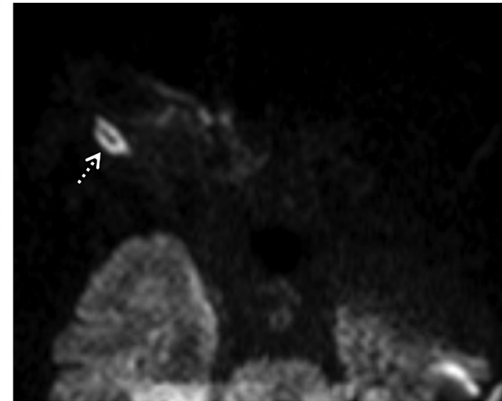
Intraorbital abscess in a 45-year-old woman. (a) Axial contrast-enhanced CT image of the orbits reveals right proptosis with globe deformity (the “guitar pick” sign) and periorbital edema with a rim-enhancing fluid collection (arrow) in the right lateral extraconal space. (b) Axial contrast-enhanced T1-weighted MR image shows the rim-enhancing fluid collection (arrow) abutting and displacing the right lateral rectus muscle. (c) Axial diffusion-weighted MR image shows restricted diffusion (arrow).
